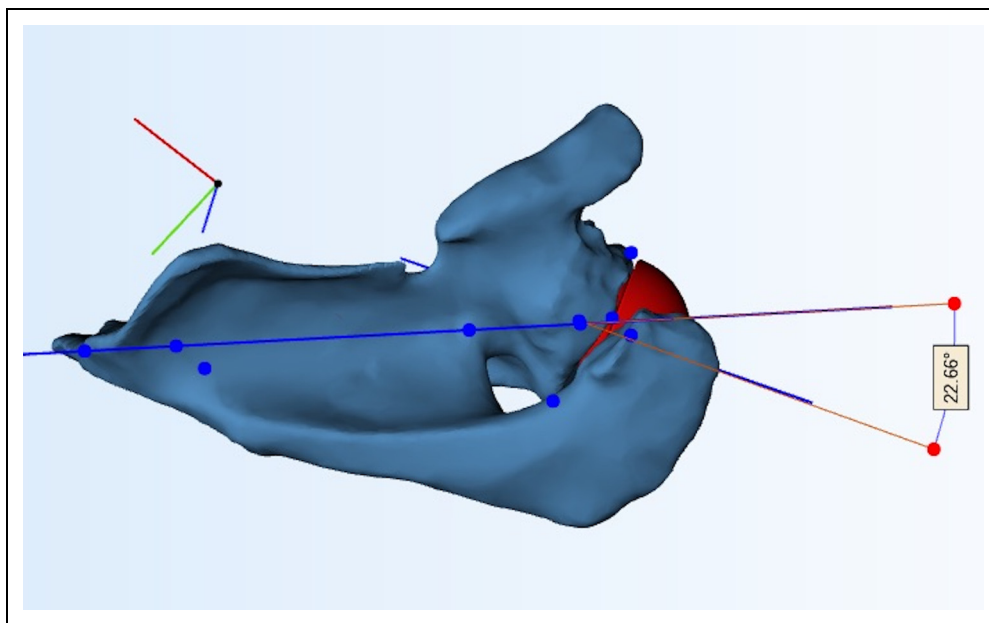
Baseplate version. Measurement of baseplate retroversion (22.6 deg) within the scapular coordinate system of the 3D CT of scapula.
